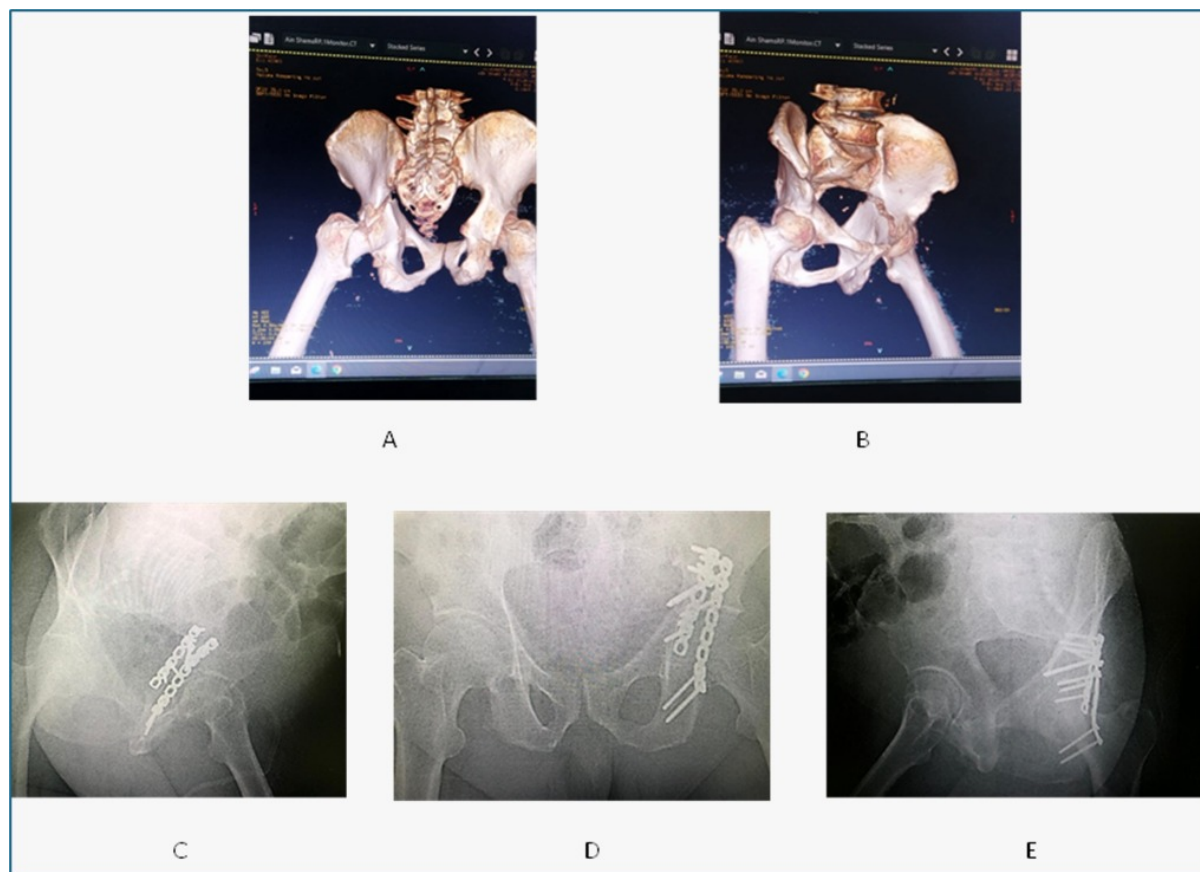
55 years old male patient, RTA, (A,B) preoperative CT scan showing transverse fracture acetabulum, (C,D,E) postoperative radiographs showing single column fixation through Kocher langenebeck approach
